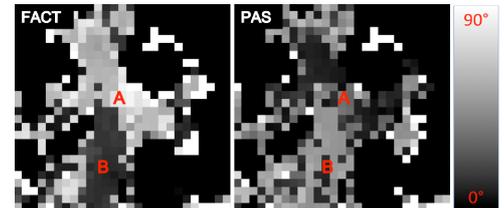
Comparison of tractograms obtained from clinical DWI data to a HARDI based reference.
